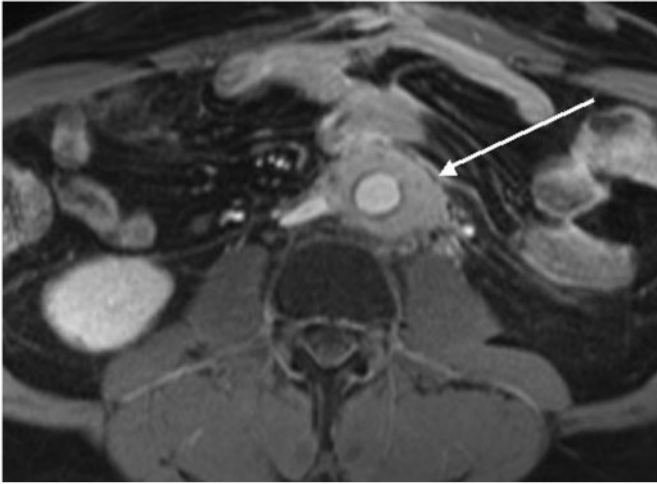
Abdominal MRI pre-treatment showing a periaortic mass encasing aorta, inferior caval vein and in part the left ureter.
